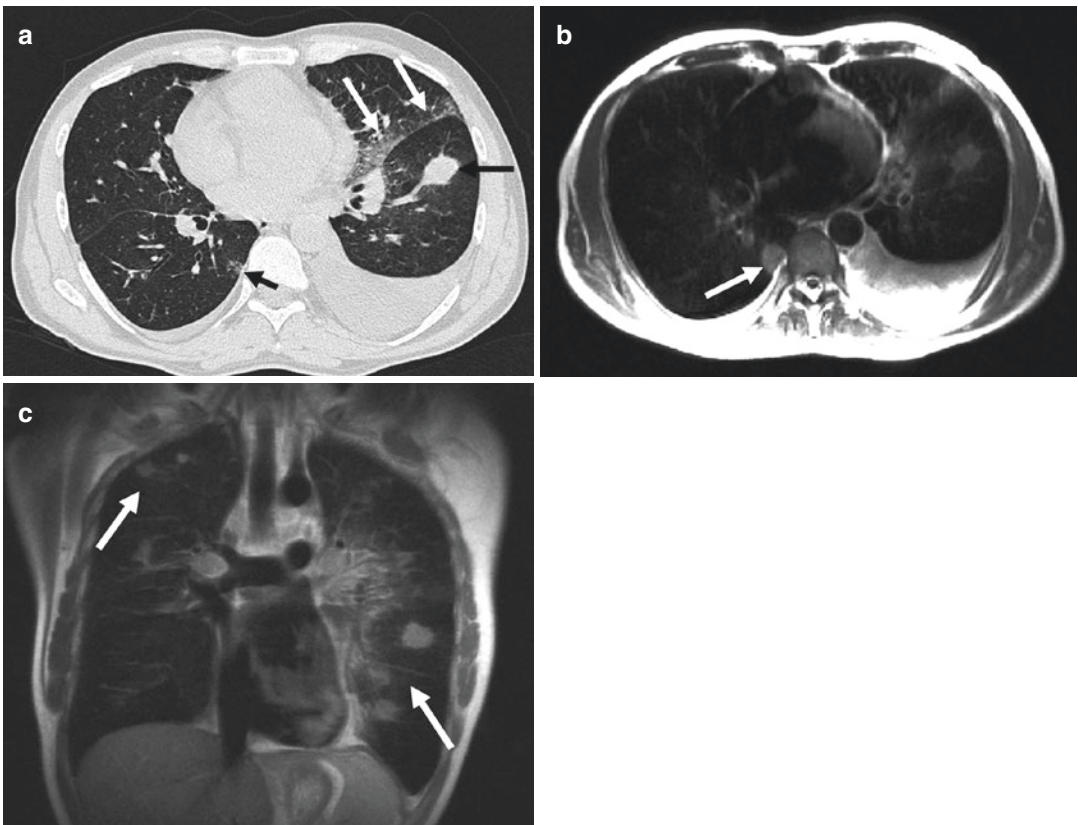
A 45-year-old male with chronic lymphatic leukemia, now suffering from angioinvasive aspergillosis (With the permission of Springer: Eibel et al. 2006a). (a) Thin-section CT below the level of the carina shows a consolidation in the left lower lobe (*black arrow*), ground-glass opacity in the lingula adjacent to the fissure (*white*
